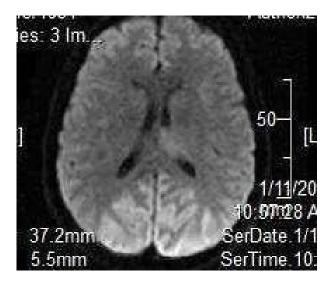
MRI with diffusion weighted imaging (DWI) showing improvement in the edema involving the thalami, occipital region and temporal lobes bilaterally.
